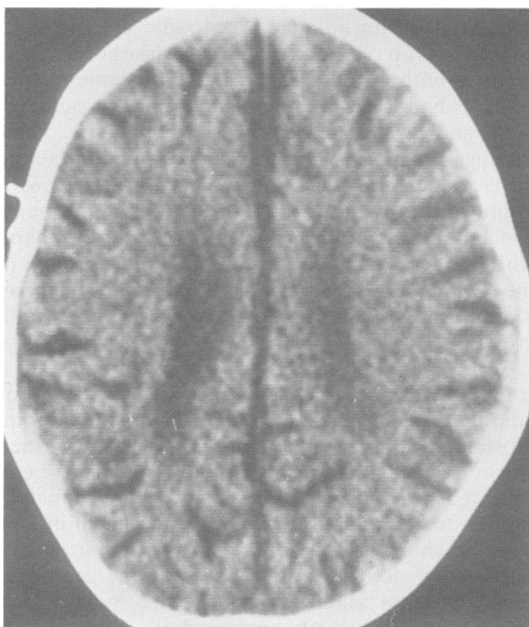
Computed tomogram of case 5, showing widened cerebral sulci and enlarged ventricles.*
